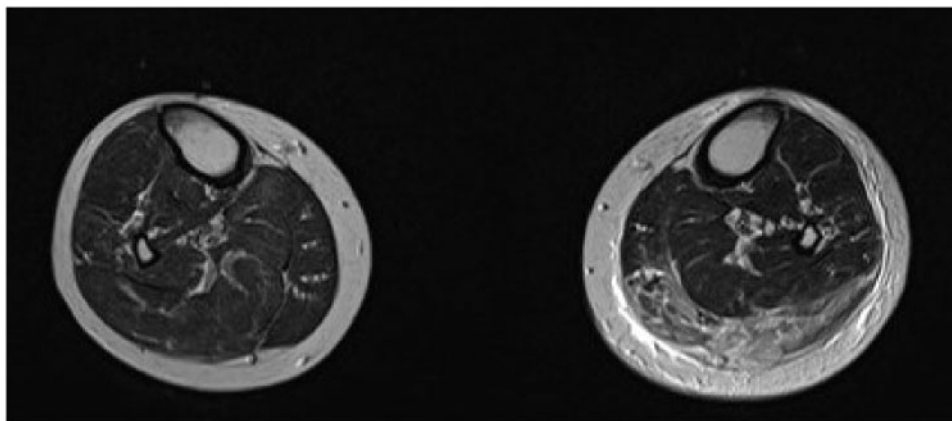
MRI of the calves
